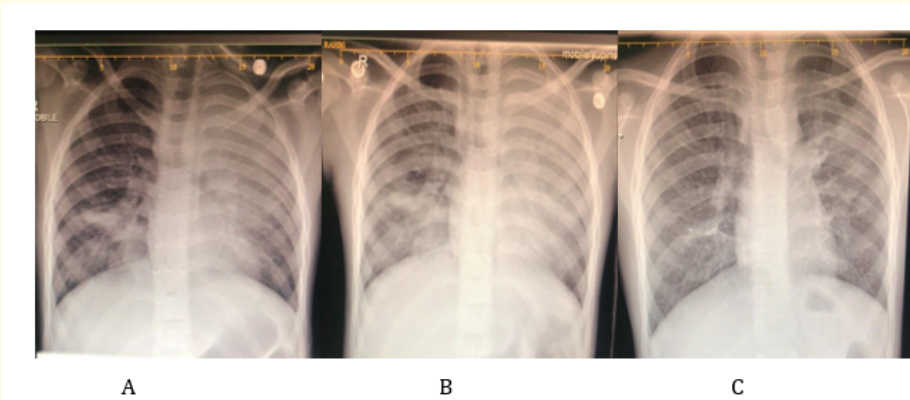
A. Chest x-ray of the child on admission with left sided consolidation, B. Chest x-ray of the same patient with worsening consolidation and pleural effusion on same day of PICU admission, C. Chest x-ray after management of the child with complete recovery of consolidation and pleural effusion.
